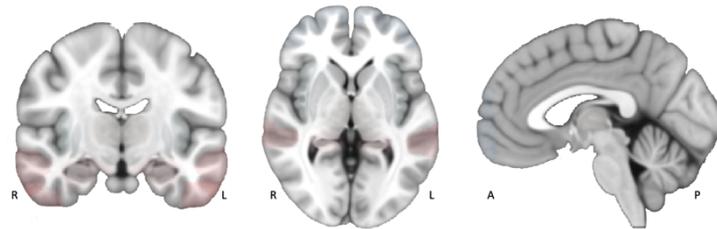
Visualization of frequency of MRI changes by region
